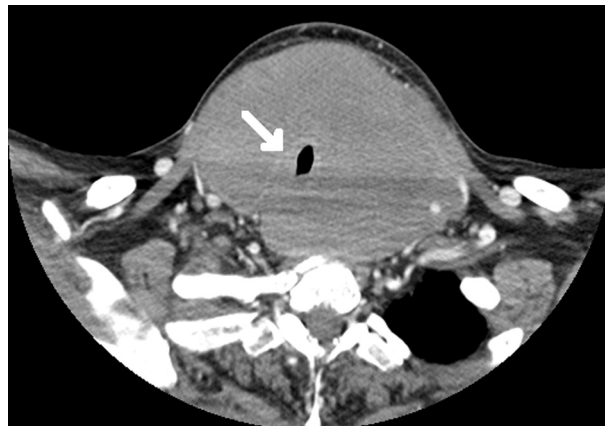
CT of the neck with intravenous contrast (axial view), demonstrating a neck mass with tracheal encasement, with rightward deviation and mass effect (arrow).
